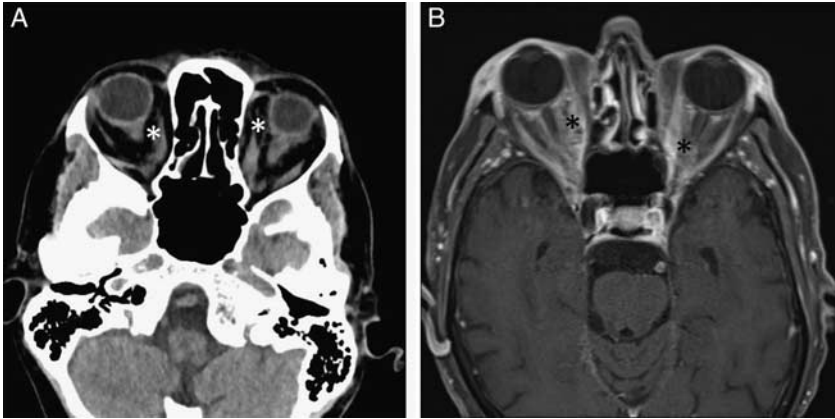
76-year-old man presented to the emergency department after being stabbed in both eyes with screw drivers. An axial computed tomographic image through the level of the orbits demonstrates ill-defined high attenuation within the intraconal spaces consistent with hemorrhage (A, white asterisks). An axial T1-weighted magnetic resonance imaging through the level of the orbits in the same patients demonstrates ill-defined T1 hyperintensity in the intraconal spaces (B, black asterisks).
